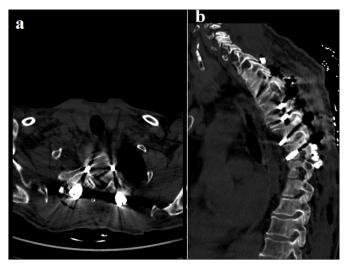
Postoperative CT images
